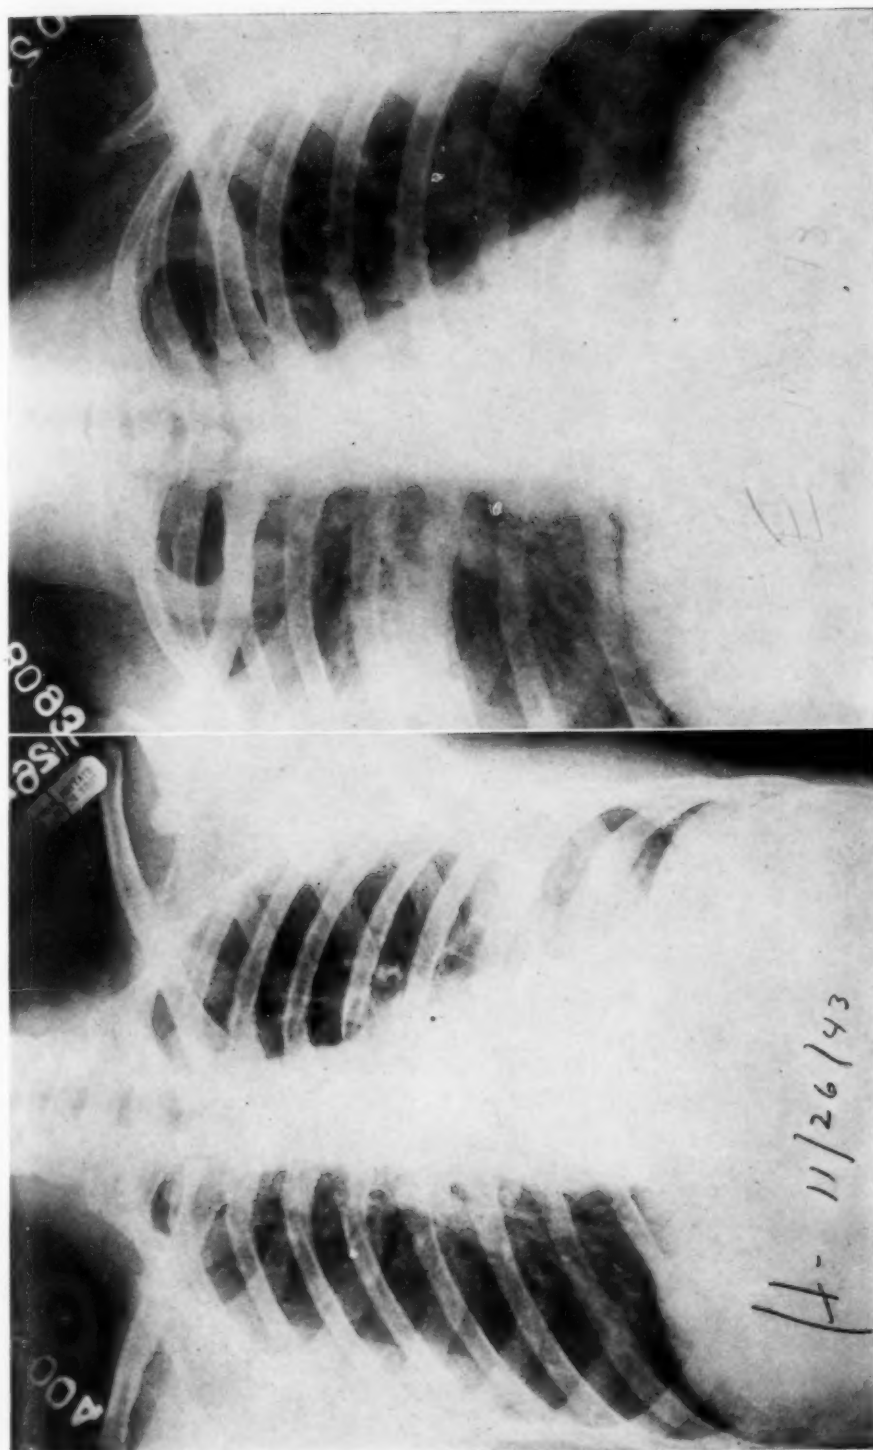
Roentgenologic characteristics of the pulmonary involvement.
